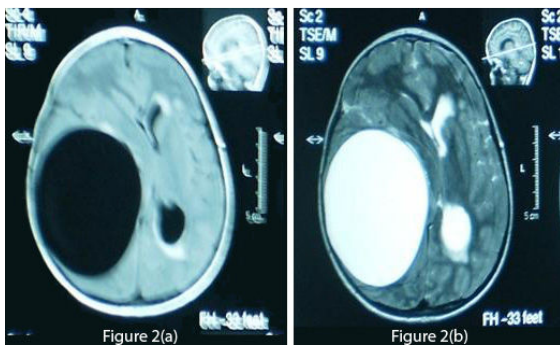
(a): T1-weighted axial MRI of the brain demonstrates a cyst density similar to CSF. Fig 2 (b): T2-weighted MRI shows no ring enhancement or oedema. The periventricular hyperintensity of the left side is probably due to obstructive hydrocephalus.
